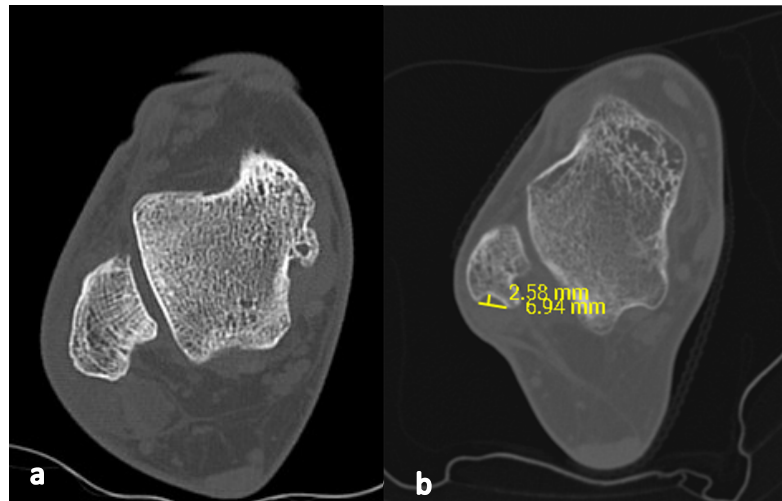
CT scan of a 47-year-old male. (a) Preoperative view. (b) Post-operative CT scan that shows the deeper neo-fibular groove.
